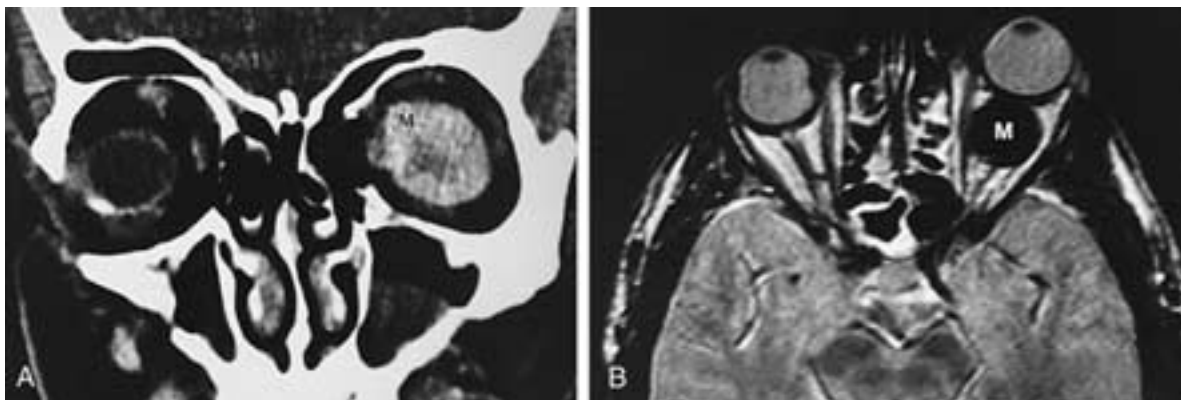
Fibrocytoma. A, Coronal contrast-enhanced CT scan shows moderately enhancing intraconal mass (*M*). B, Axial T2-weighted MR image shows markedly hypointense mass (*M*). This is related to marked dense collagen content. (From Dalley RW. Fibrous histiocytoma and fibrous tissue tumors of the orbit. *Radiol Clin North Am* 1999;37:185–194.)
